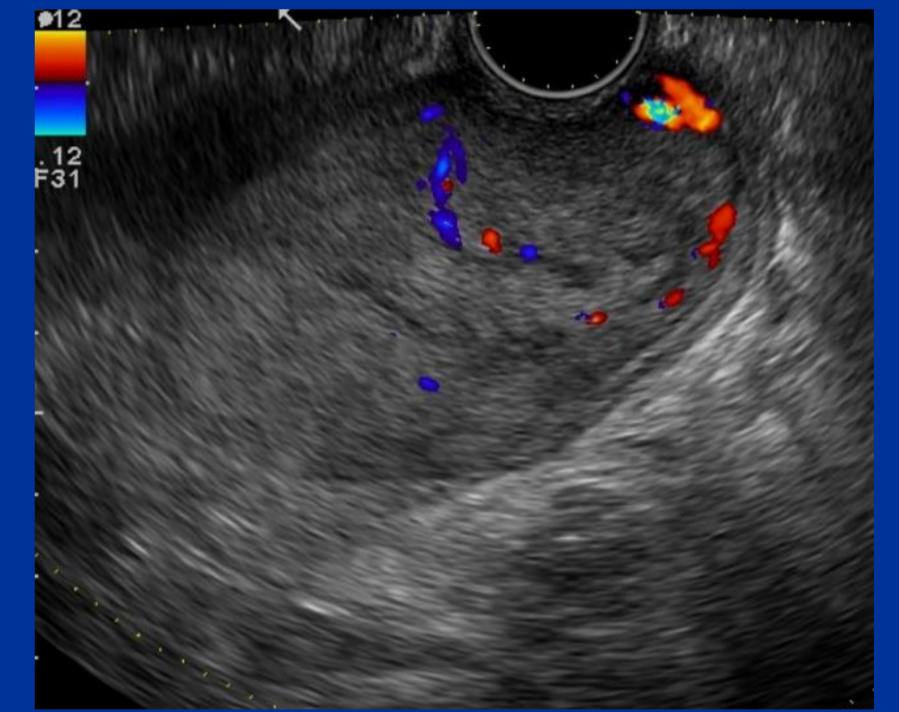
The region demonstrated flow on Colour Doppler Imaging.
